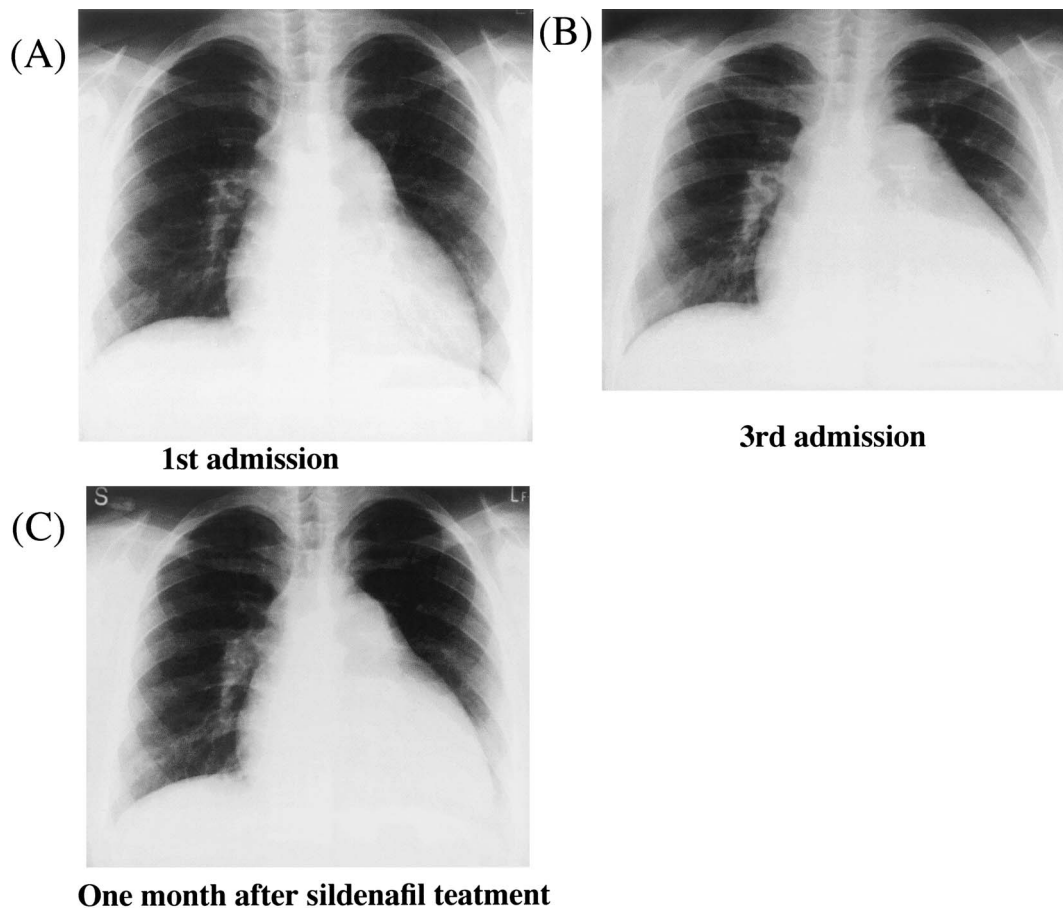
Chest roentgenographic changes. The cardio-thoracic ratio (CTR) increased 3 months after the combination therapy of beraprost and saproglerate (B) compared to that on the first administration (A), but decreased after changing to sildenafil (C).
